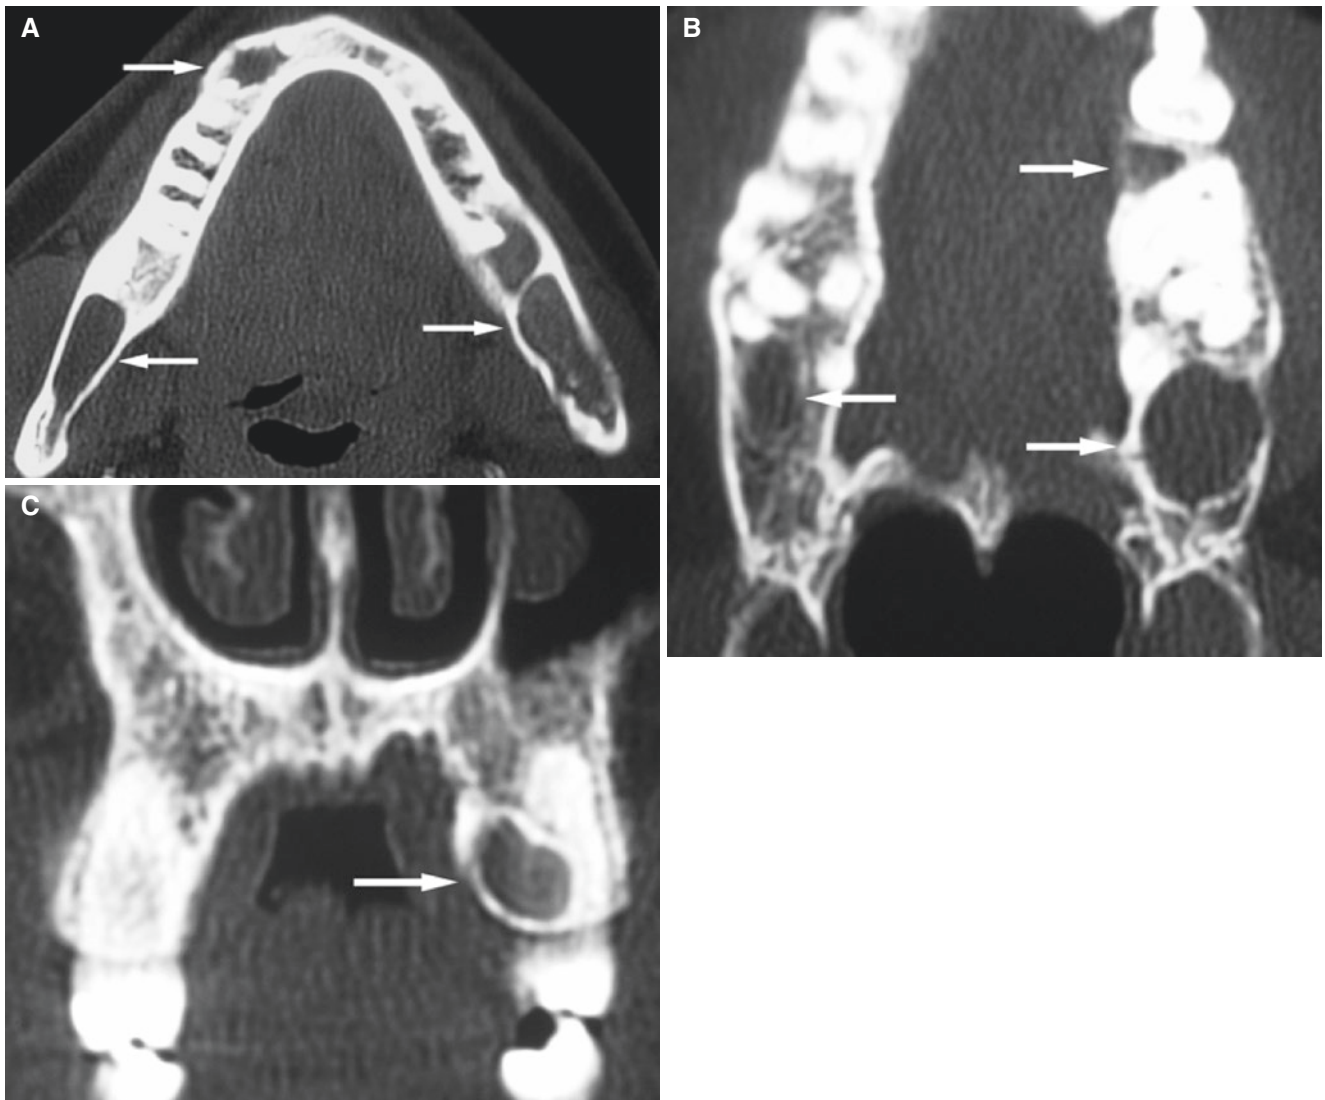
Keratocystic odontogenic tumor, maxilla and mandible; Gorlin–Goltz (basal cell nevus) syndrome. (A) Axial CT image shows three cystic tumors in mandible (*arrows*). (B) Axial CT image shows
